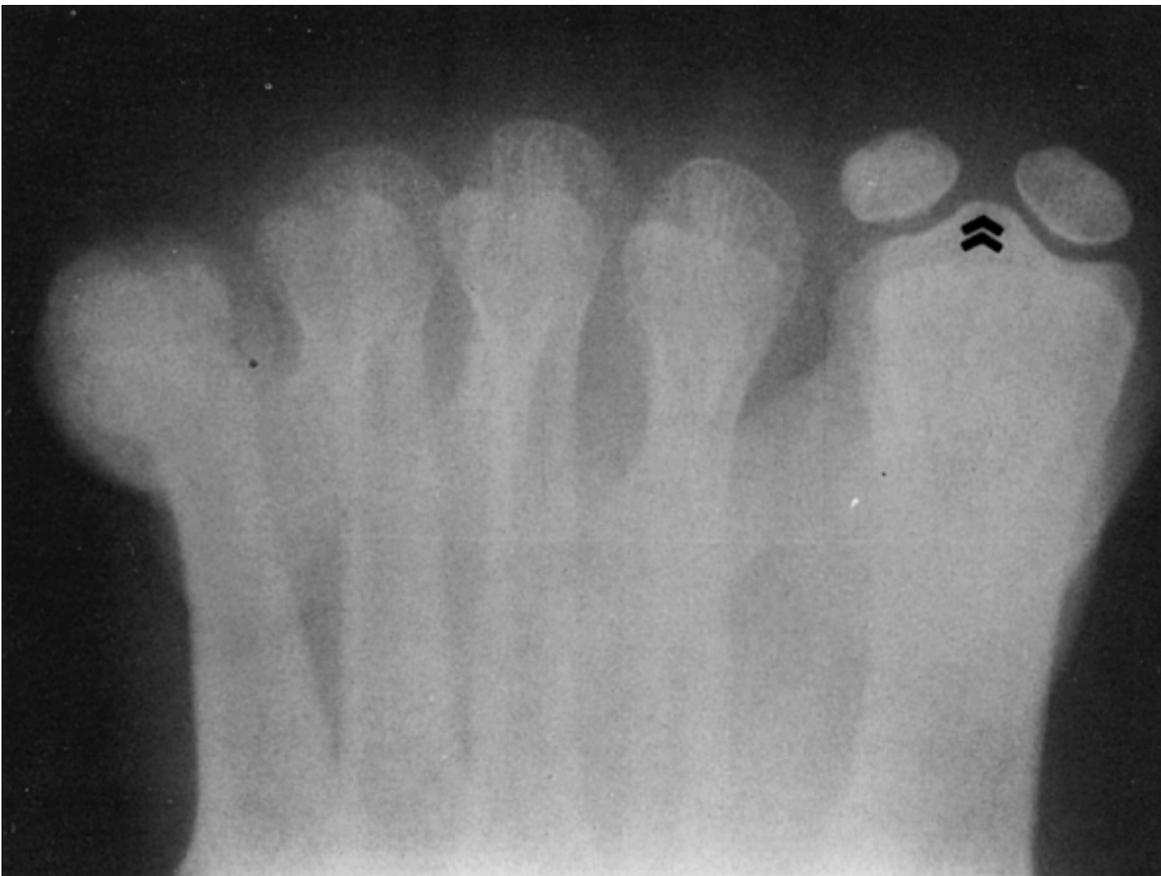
30 The intersesamoidal ridge or crista is well seen on an axial radiograph. (© M. J. Coughlin. Used by permission.)
